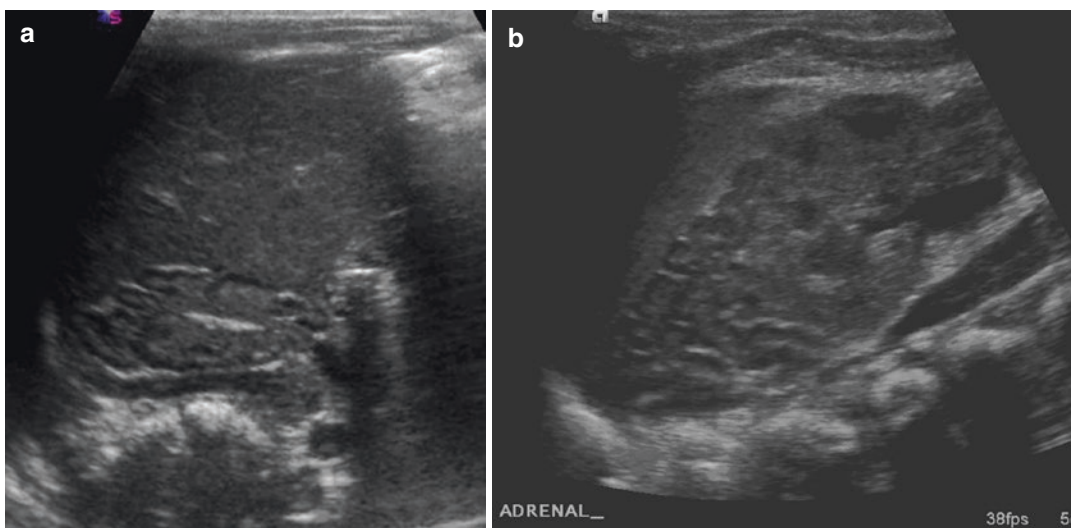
Ultrasound suprarenal region in CAH: (a) Note enlarged appearance to the adrenal gland with increased number of gyrations giving a coiled, cerebriform appearance. (b) Transverse image demonstrates cerebriform appearance of CAH
